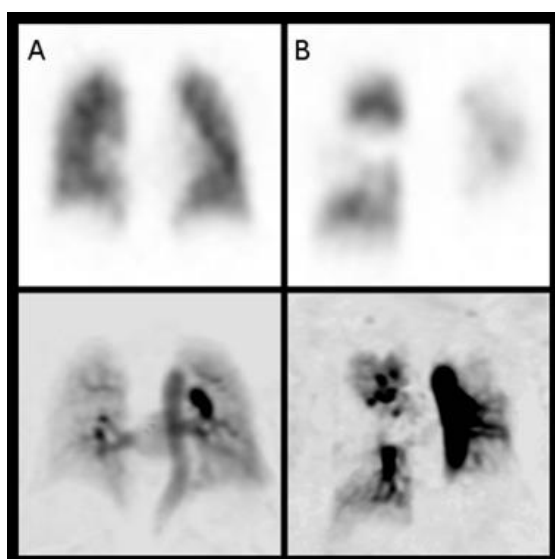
SPECT and DCE MRI perfusion images.
